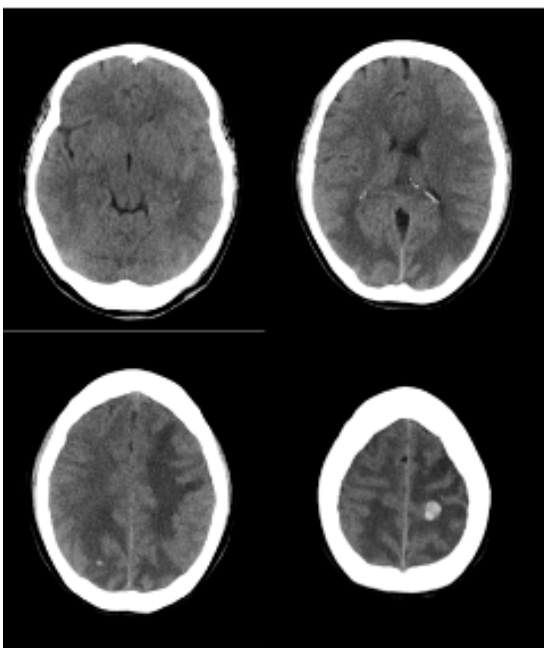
Subsequent axial brain CT scan
